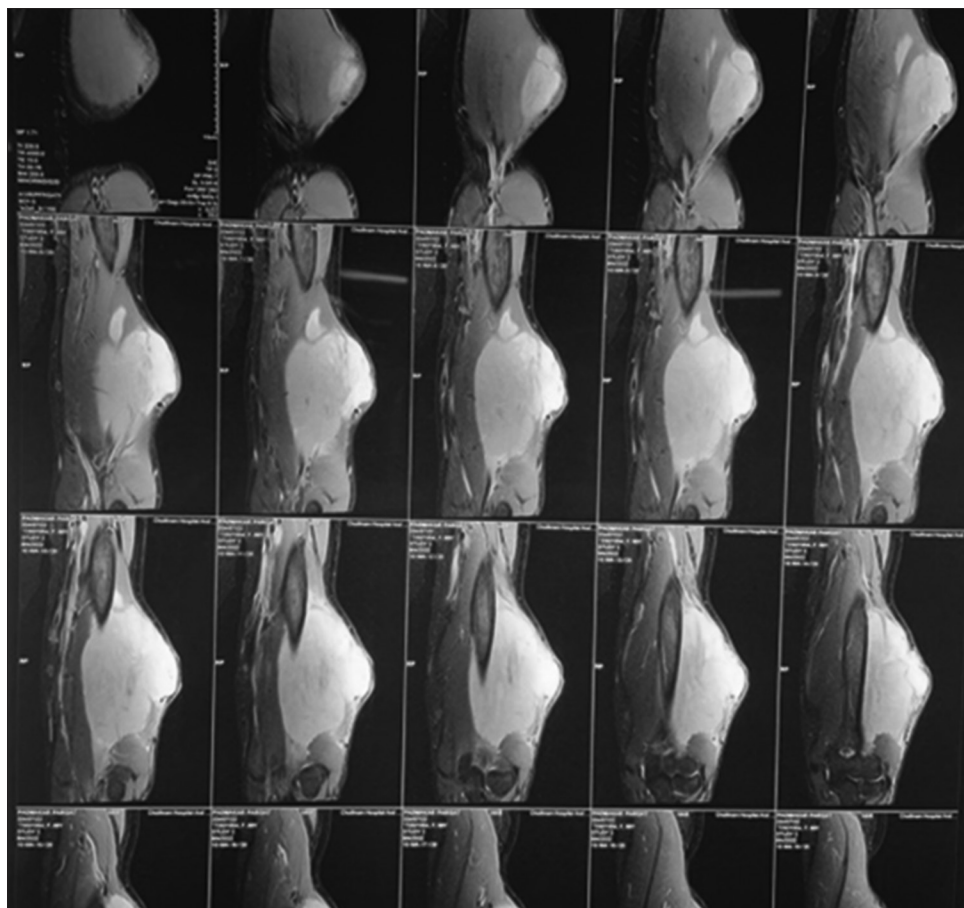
MRI- Showing extent oftumor
